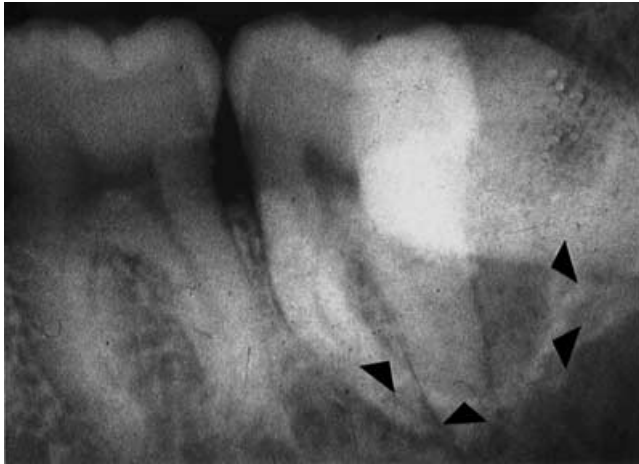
Intraoral radiograph revealing an IPC/2nd mandibular molar (37) showing the cystic lesion overlying the roots (arrows, case 4; Table 1).
